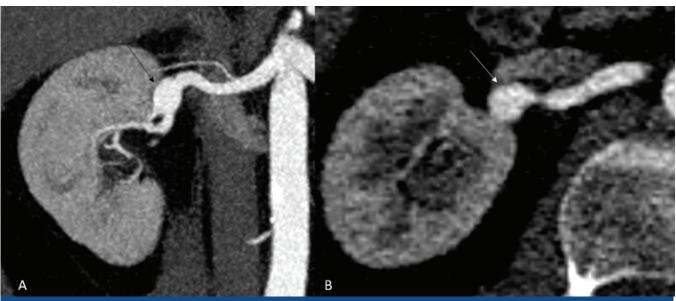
Contrast-enhanced CT angiography showing a right renal artery aneurysm. A) maximum intensity projection reconstruction (oblique coronal), black arrow. B) axial plane, white arrow.
